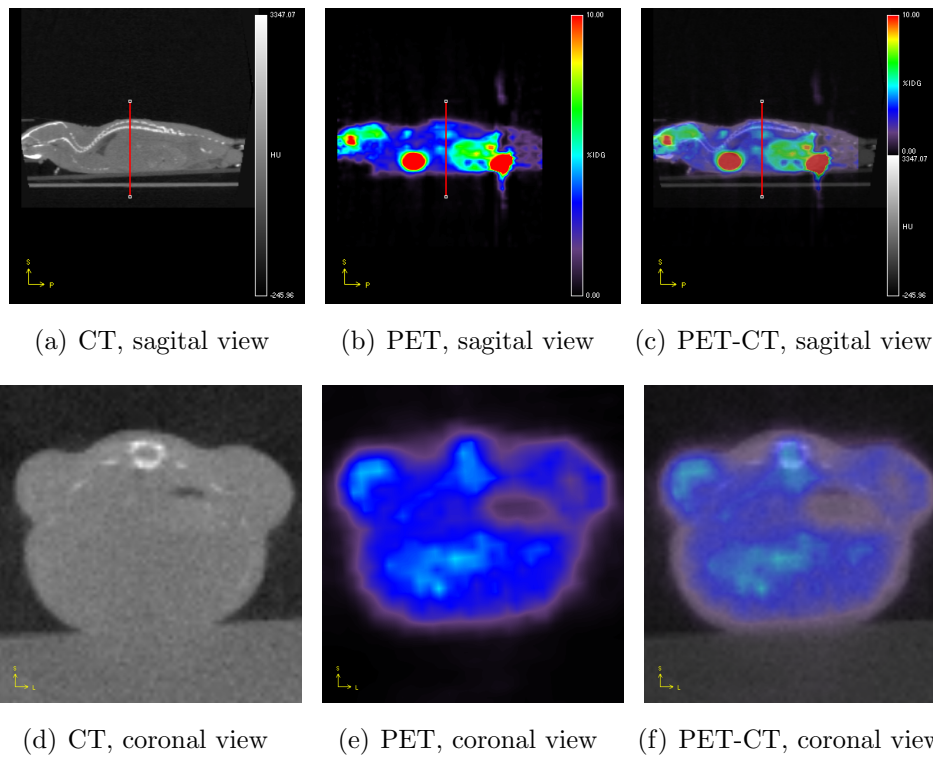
PET-CT fusion in sagittal and coronal views. *Red line indicates the coronal view.*
